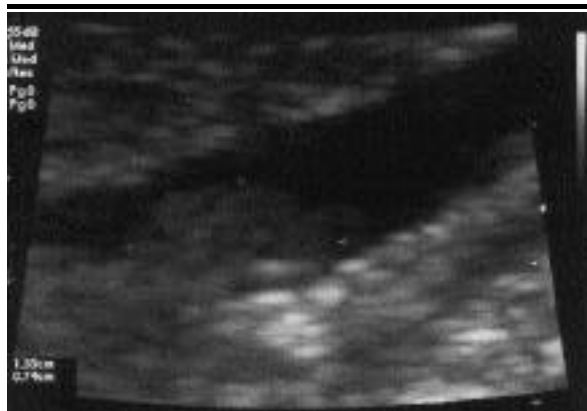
Patient no. 1. Doppler ultrasound showing a large thrombus in the lumen of the inferior vena cava.
